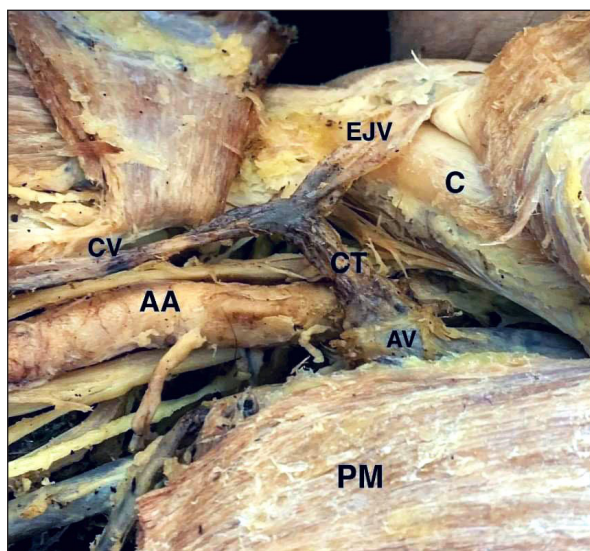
The region of the right deltopectoral triangle. The EJV joins the right cephalic vein with a common trunk (red arrow) that corresponds to a jugulocephalic vein that finally drains into the axillary vein. C=Clavicle; EJV=External jugular vein; CV=Cephalic vein; CT=Common trunk between CV and EJV; AA=Axillary artery; AV=Axillary vein; PM=Pectoralis major muscle.
